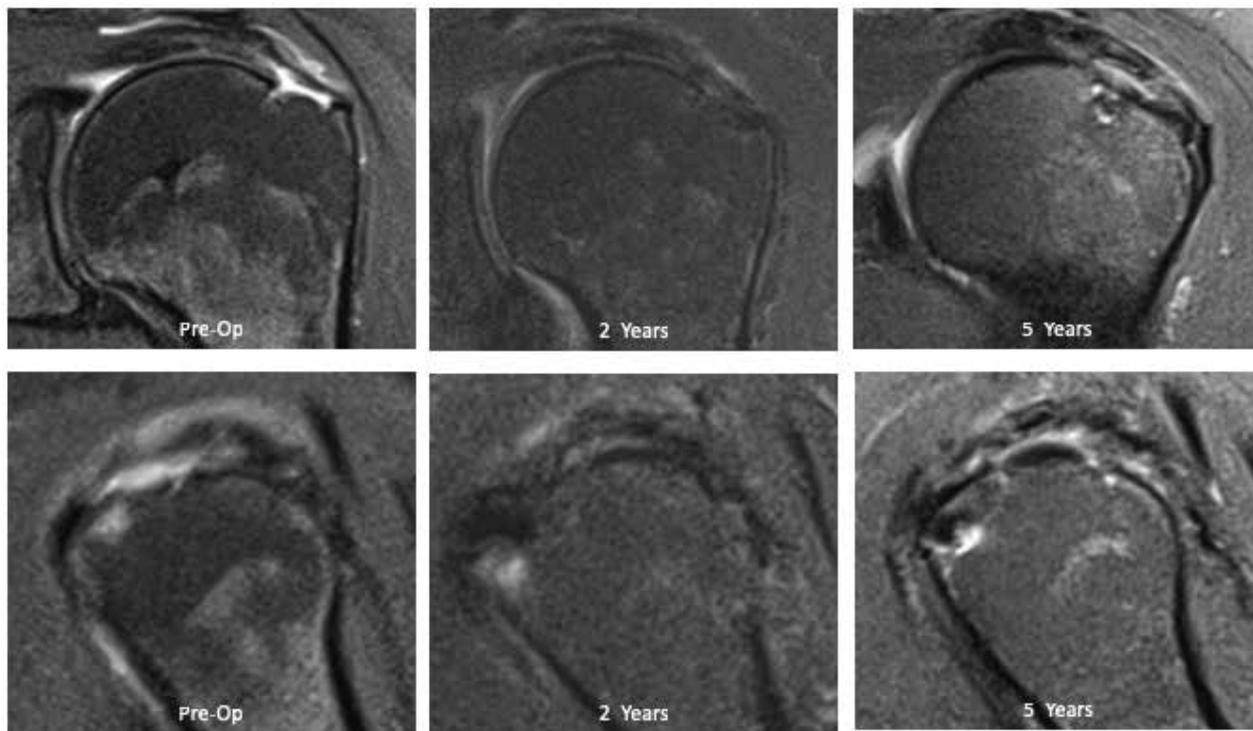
MRI images of high-grade, articular-sided partial-thickness tear. At 5 years a new, small defect was noted at the posterior edge of the implant site, while the original, very large defect was more toward the anterior edge.
